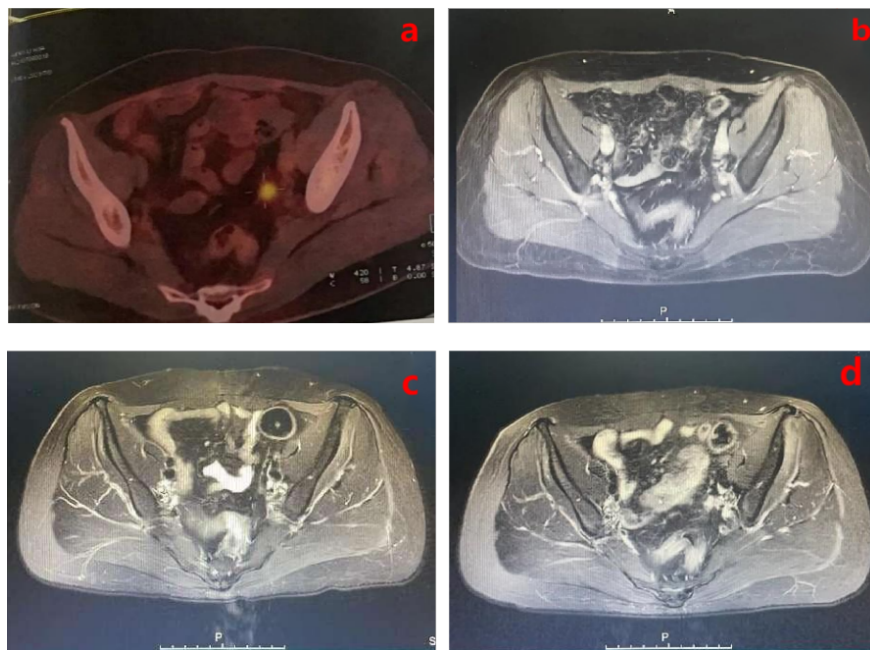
a: PET-CT showing recurrent metastatic lesions on 28 July 2021;b: pelvic MR examination on September 2021, CR assessed;c: pelvic MR examination on February 2023, CR assessed;d: pelvic MR examination on October 2023, CR assessed.
